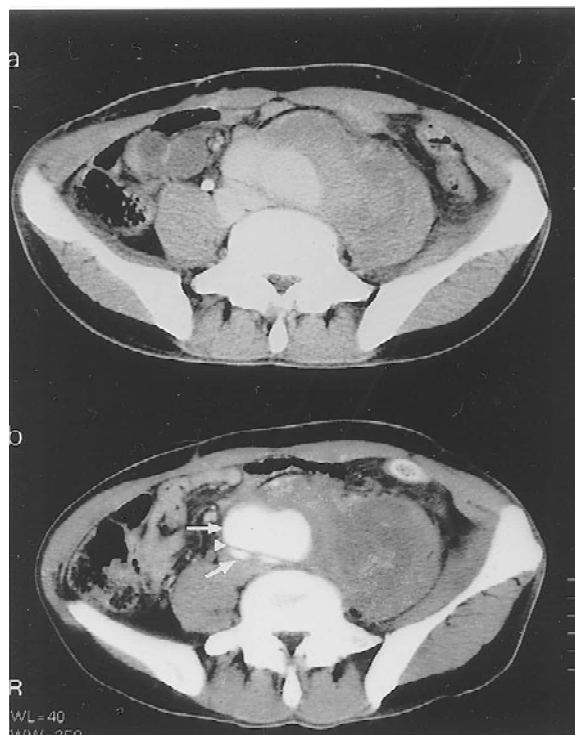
a : Abdominal CT scan showing a distinct mass measuring $12 \times 15 \times 10$ cm in the left retroperitoneal space, with involvement of the aorta. b : An abdominal CT scan revealed two distinct lumens (arrows) with a visible flap in the abdominal aorta (arrowhead).
